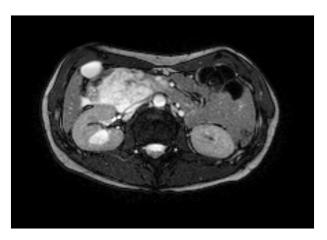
T2-weighted MR images of Case 1 in which a high signal intensity cystic mass with septations is seen.
